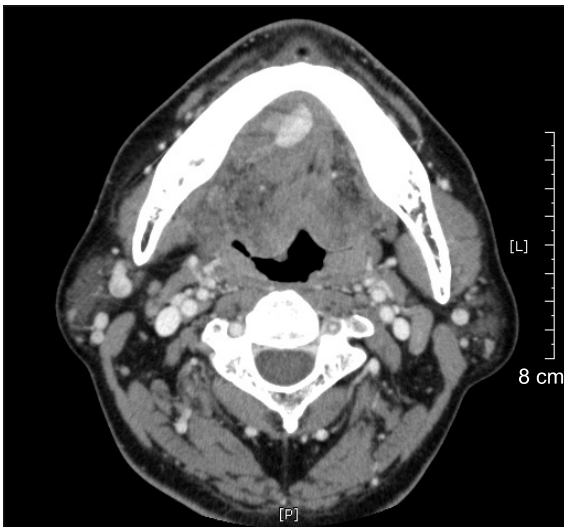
Axial computed tomography image showing hemorrhage on the mandibular anterior lingual side.
